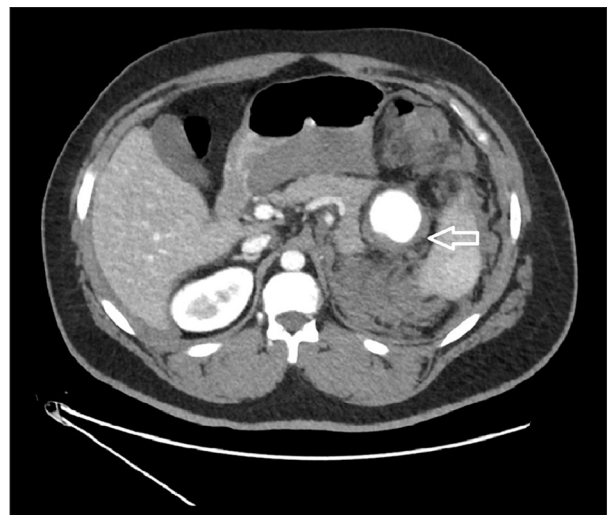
Abdominal CT scan with IV contrast showing the 5-cm splenic artery aneurysm in the splenic hilum displacing the tail of the pancreas, with adjacent retroperitoneal and peri-splenic hemorrhage.
